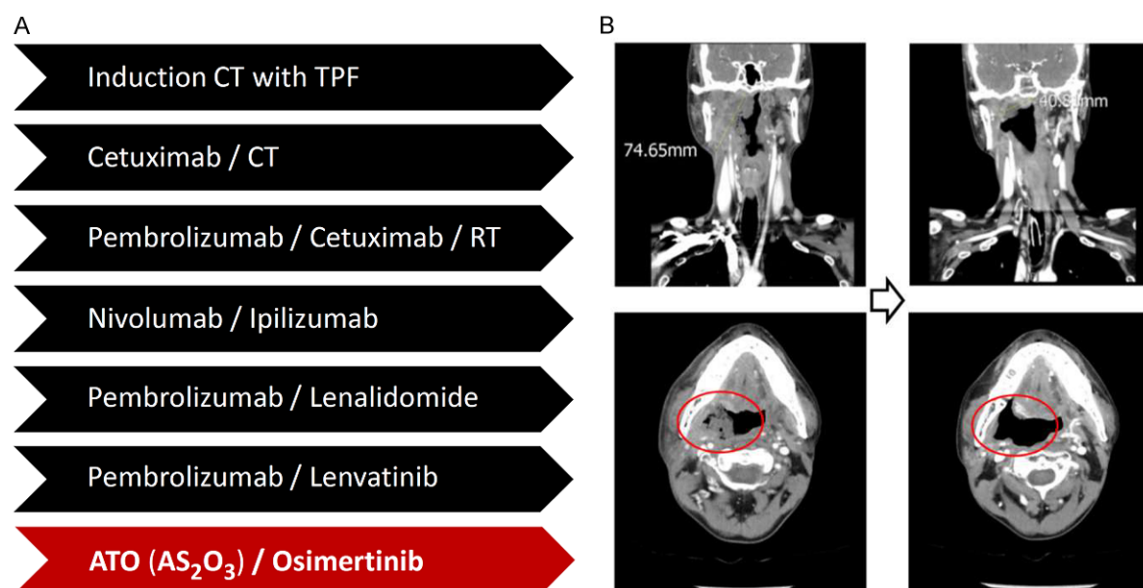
Patient treatment and the therapeutic assessment. A. The treatment processes of the patient from Jul/2019 to Apr/2021. B. The therapeutic evaluation of computed tomography in the patient before and after four weeks of ATO and AZD treatment.
